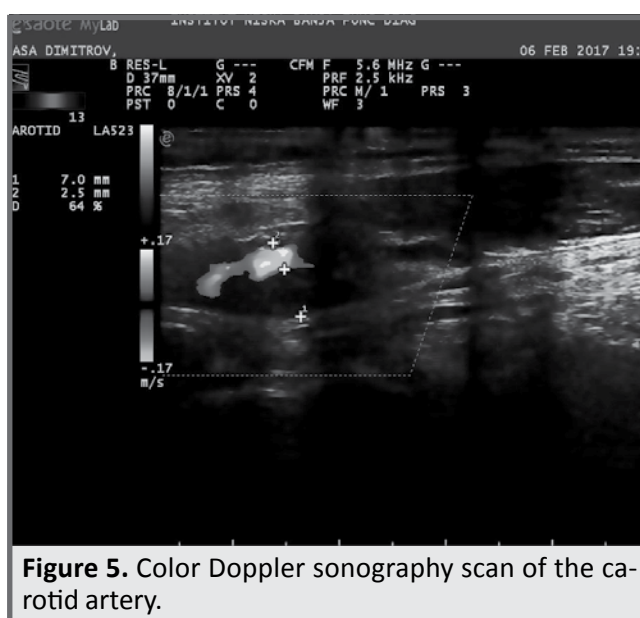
Color Doppler sonography scan of the carotid artery.
